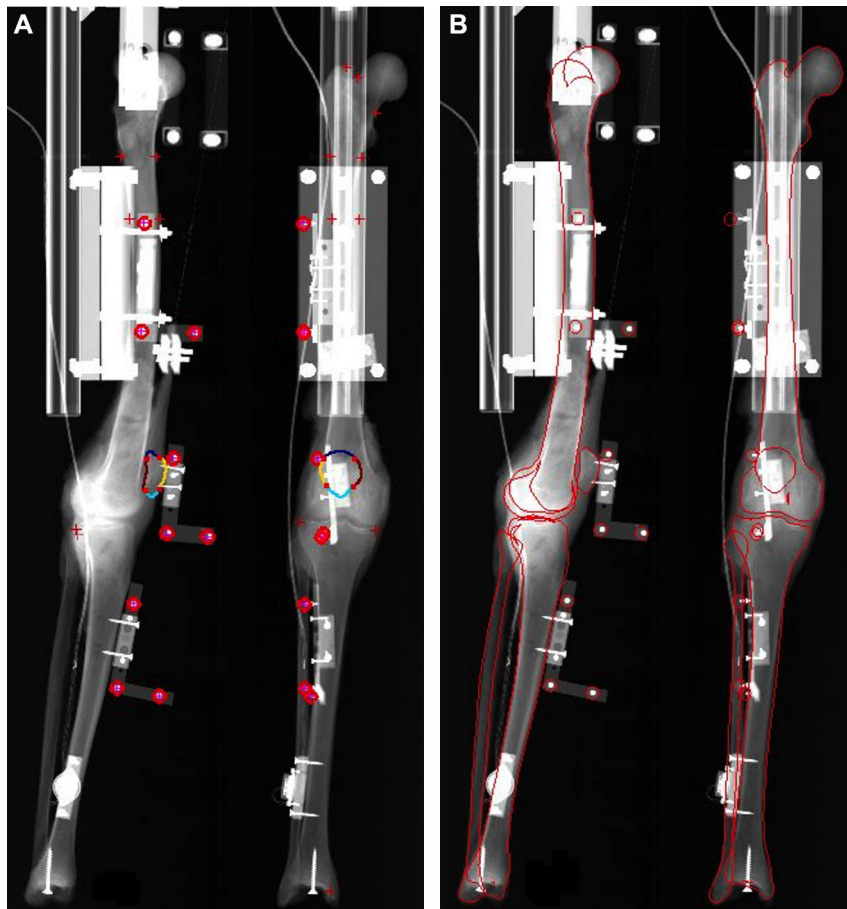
3D reconstruction in the reference position based on biplanar radiographs. A. Selection of femoral landmarks and identification of the patellar contours and tripods. B. Reconstruction using a 3D algorithm.
